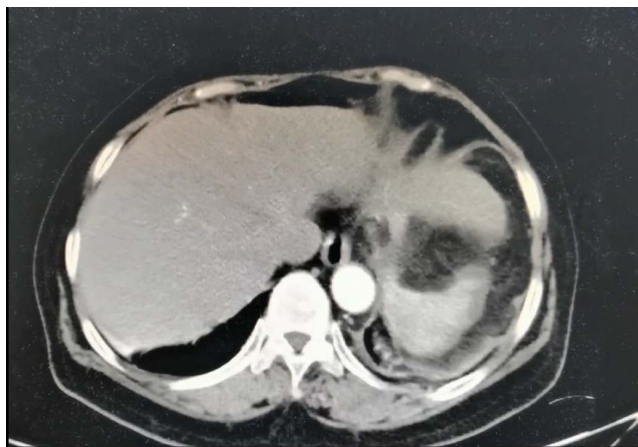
Preoperative CT images: the lesion located in the S2 segment of the liver is displayed.
